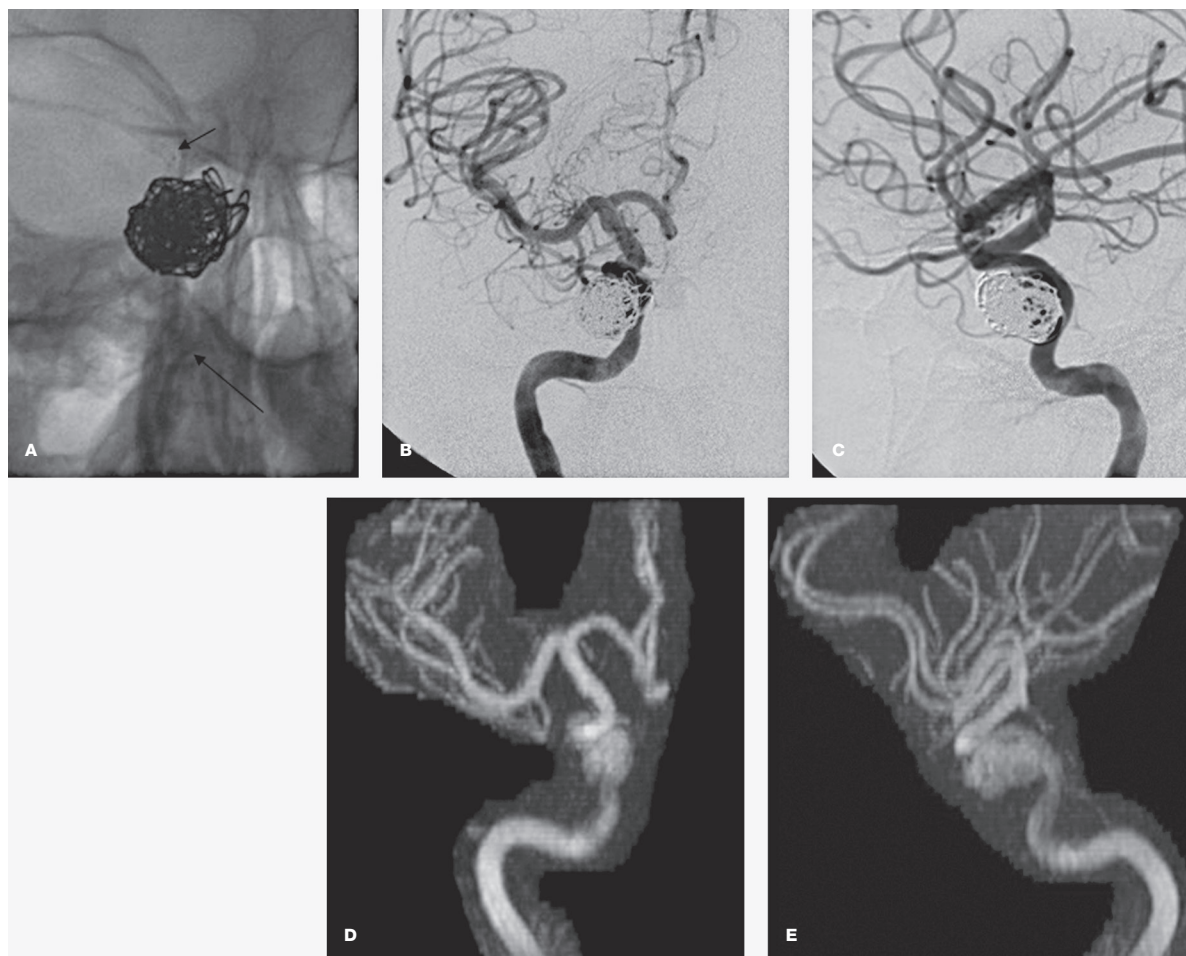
Aneurysmal remnant larger on CE-MRA than on IA-DSA. A) A giant cavernous carotid aneurysm post stent-assisted coiling with an Enterprise stent. AP plain film shows the coil mass and the stent marker bands (proximal marker bands – long arrow, distal marker bands – short arrow). IA-DSA (B and C) of the right carotid artery and matching MIP views of CE-MRA (D and E) performed 2 days apart demonstrate a large aneurysmal remnant. The remnant is depicted on both modalities however its full extent is not appreciated on the IA-DSA as it is on the CE-MRA. Parent artery stenosis is noted similarly on both modalities. There is no “marker band effect” since the proximal and distal marker bands of stent are within the internal carotid artery which is a relatively large vessel.
